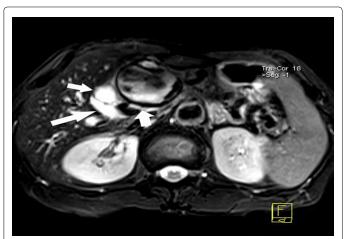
Axial planar T2-wegithed MRI shows dilation of cystic duct (short arrow) and common bile duct (long arrow) compressed by pseudoaneurysm (fat short arrow)
